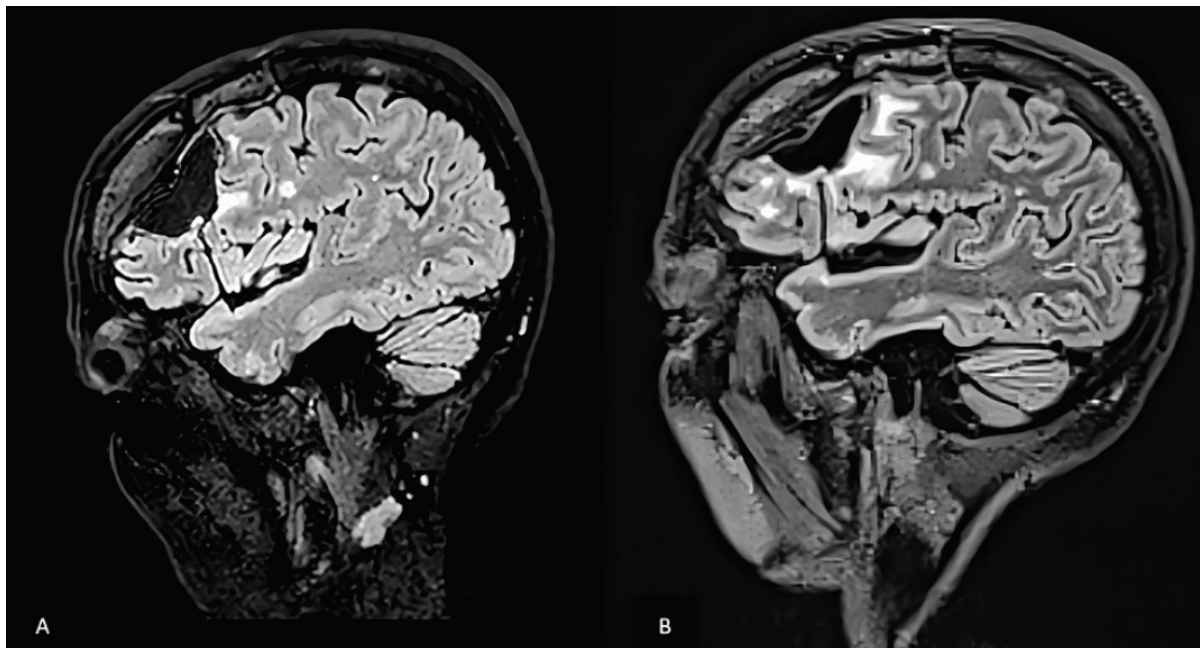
A: A brain MRI of case 1 was performed in March 2020, confirming a new lesion in the right frontal lobe. B: Brain MRI performed in May 2020 with evidence of intracranial stable disease. MRI – magnetic resonance imaging.
